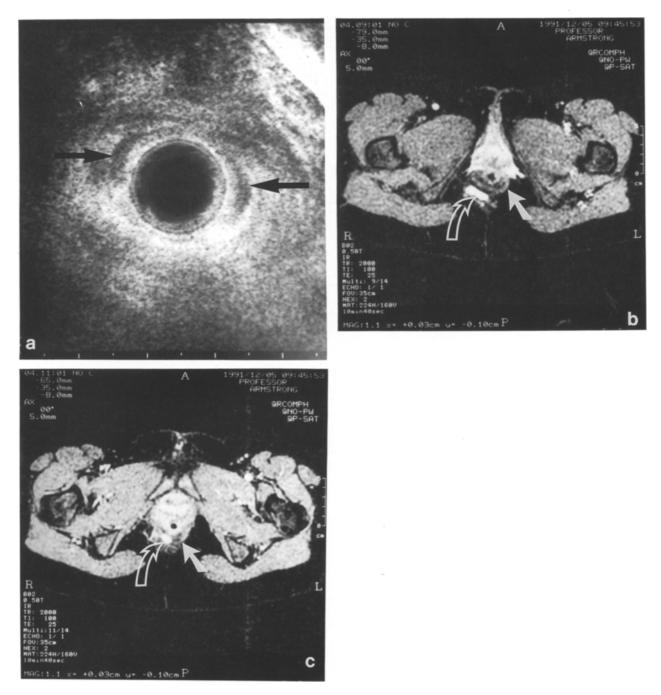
Sonographic image (a) of the sphincter in a patient in whom previous surgery has led to extensive internal sphincter disruption and scarring of the external sphincter (arrows indicate remnants of internal sphincter). A fistula tract is difficult to identify in this situation. Axial STIR MRI images (b and c) of the same patient, however, show a tract (open arrow) running outside the external sphincter (closed arrow) in (b) which at a higher level (c) is seen in the intersphincteric space. Findings at operation confirmed the MRI assessment of a transsphincteric fistula. Anterior is at the top of parts a to c.
